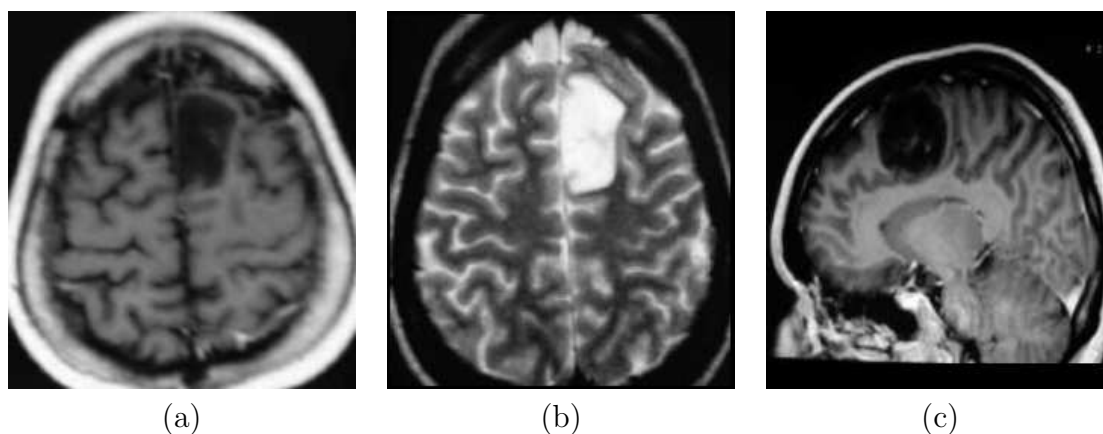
Low grade astrocytoma. a) An axial slice of a T1-weighted image. b) An axial slice of a T2-weighted image. c) A sagittal slice of a contrast enhanced T1-weighted image [Emedicine, 2005].
